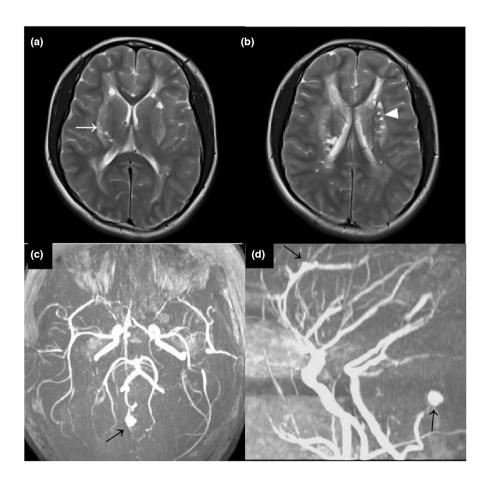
Brain MRI on admission. (a, b) Axial T2WI images. (c, d) MRA. Leukoencephalopathy (white arrow) was noted in the deep white matter and external capsule on T2WI images. Most of the lacuna or cysts (arrowhead) were located within the white matter lesions. Calcifications on CT were not evident on MRI. Aneurysms in posterior inferior cerebellar artery and anterior cerebral artery were seen on MRA (black arrows).
